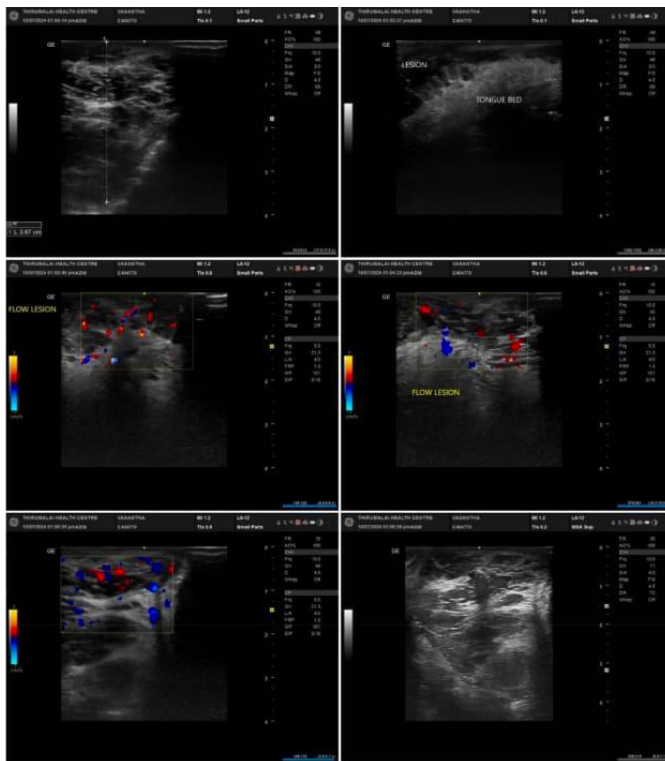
Color Doppler imaging showing prominent vascular flow within the tongue lesion.
